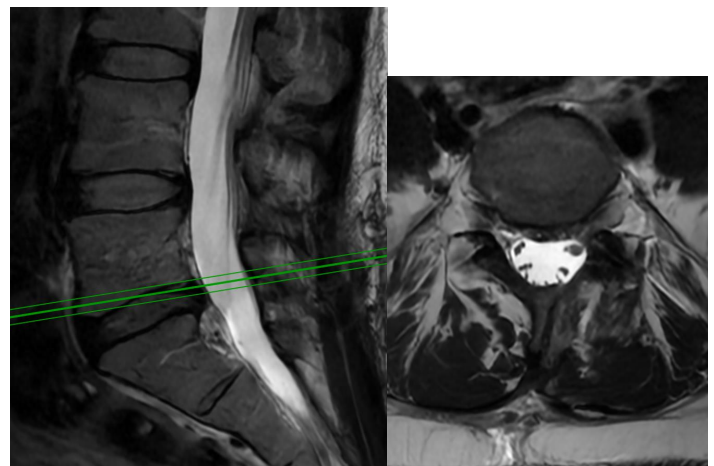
At 6 months, a post-operative MRI shows the complete resection of the L5-S1 disc herniation with central spinal canal decompression and L5 and S1 nerve root decompression achieved on both sides.
